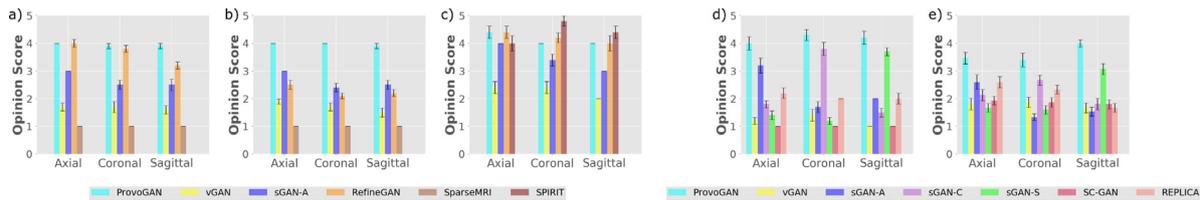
Methods were compared in terms of radiological opinion scores for three reconstruction tasks: a) single-coil reconstruction of T₁-weighted images undersampled by $R = 8$ in the IXI dataset, b) single-coil reconstruction of T₂-weighted images undersampled by $R = 8$ in the in vivo knee dataset, and for two synthesis tasks: d) many-to-one synthesis task of T₂, PD → T₁ in the IXI dataset, e) many-to-one synthesis task of T₁, T₂, T_{1c} → FLAIR in the in vivo brain dataset. The quality of the recovered axial, coronal, and sagittal cross-sections were rated by an expert radiologist by assessing their similarity to the reference cross-sections via a five-point scale (0: unacceptable, 1: very poor, 2: limited, 3: moderate, 4: good, 5: perfect match). Figure legends denote the colors used for marking the methods under comparison.
